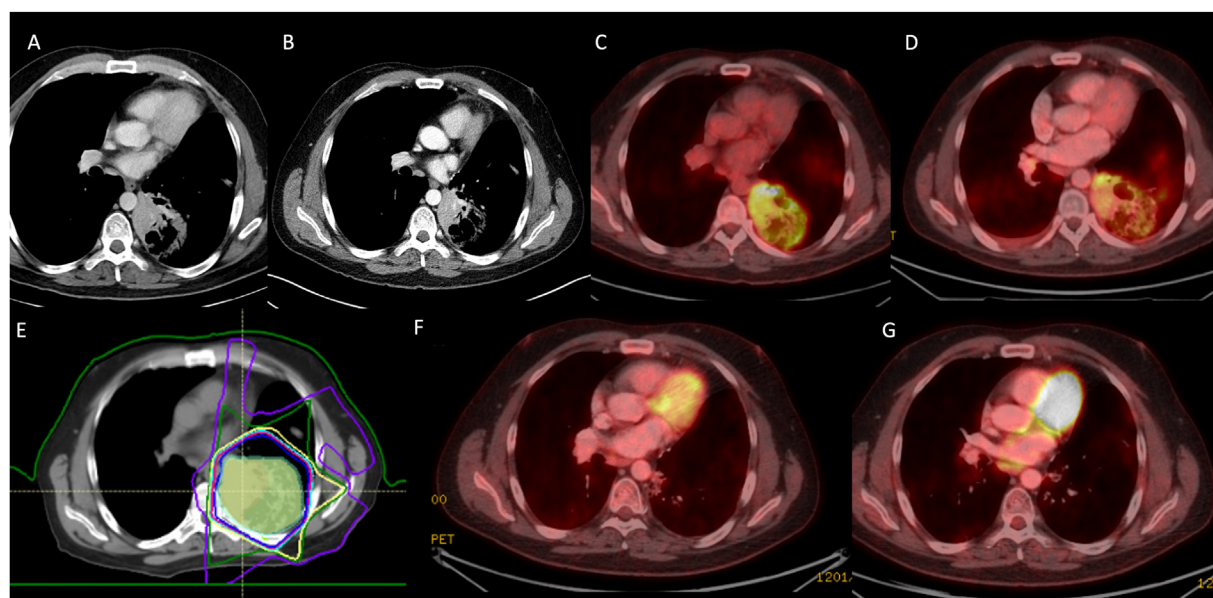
A 47-year-old man with a history of recurrent lung infections refractory to antibiotics and biopsy-proven lung mucosa-associated lymphoid tissue lymphoma (A) prior to therapy, (B) after weekly rituximab \times 4 with improvement, (C) subsequent progression on positron emission tomography (PET)/computed tomography (CT), (D) with slight improvement following a 3-month trial of zanubrutinib, which was discontinued due to hemoptysis. He had a biopsy redemonstrating mucosa-associated lymphoid tissue lymphoma prior to (E) ultra-low-dose radiation therapy, 4 Gy in 2 fractions, with (F) a complete metabolic response on PET/CT 2 months later with a Deauville score of 2, and (G) ongoing response 26 months following radiation.
